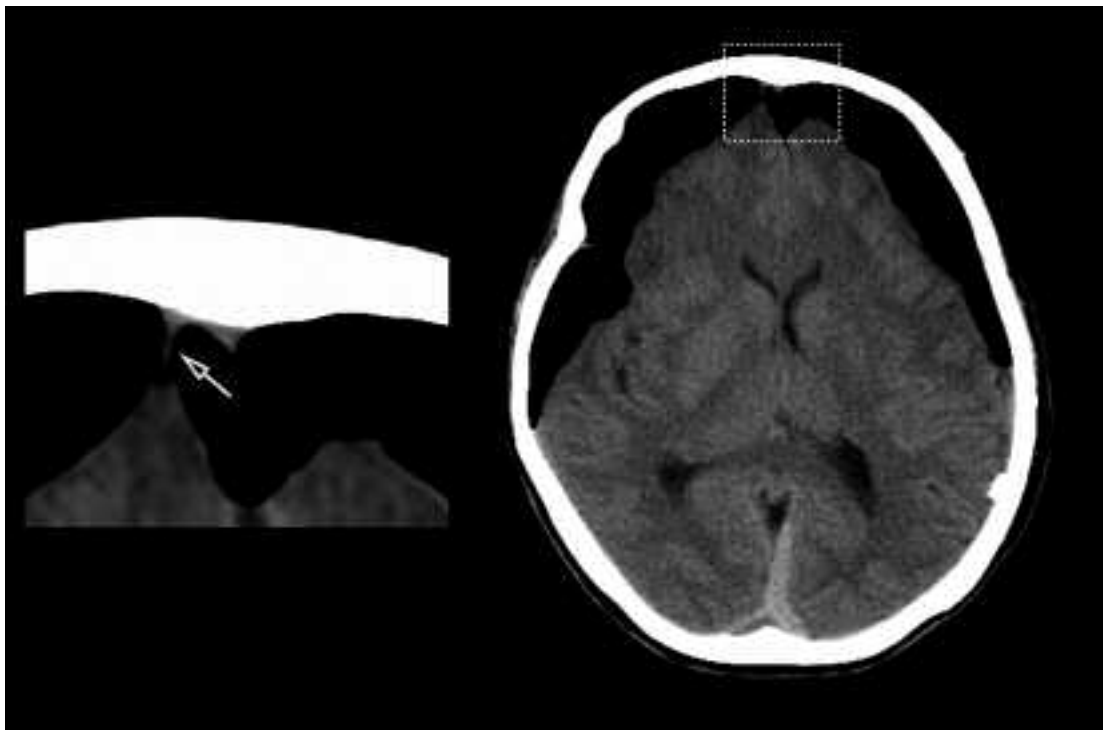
Uninfused axial CT scan demonstrating bilateral tension pneumocephalus. Note the presence of a bridging vein in the right frontal region (see inset).
